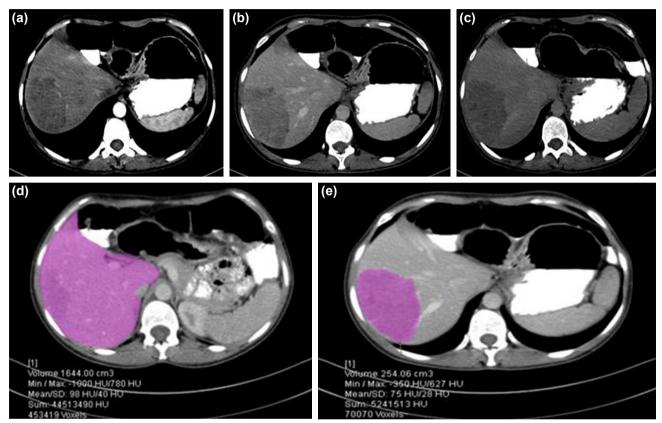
(a-c) Computed tomography (CT) scans in the arterial-venous and 5^{th} -min venous phase show an irregular hypodense large mass in segment 7–8. (d, e) Non-contrast CT scans volumetric calculation of HCA.
